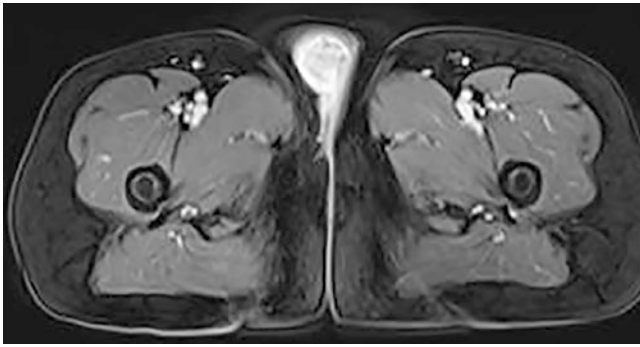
Axial and sagittal contrast-enhanced fat-suppressed T1-weighted images: the lesion showed significant homogeneous enhancement and clear boundary after contrast enhancement
